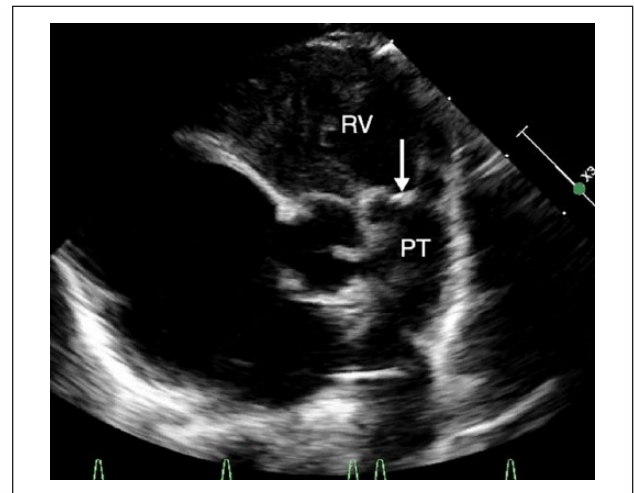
Parasternal short-axis echocardiographic view suggests membranous pulmonary atresia (arrow). This must be confirmed on color Doppler with a low Nyquist limit. PT, pulmonary trunk; RV, right ventricle.
